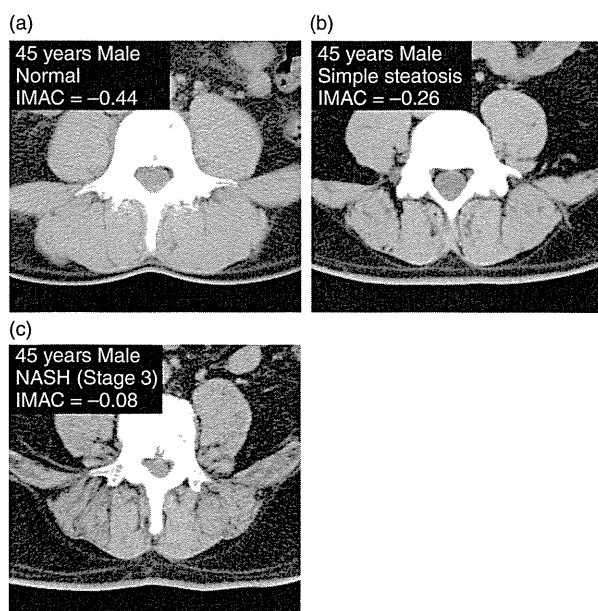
Cross-sectional computed tomographic images of the subfascial muscular tissue in the multifidus muscle taken at the umbilical level in a normal individual (a), a patients with simple steatosis (b), and a patient with non-alcoholic steatohepatitis (c).
